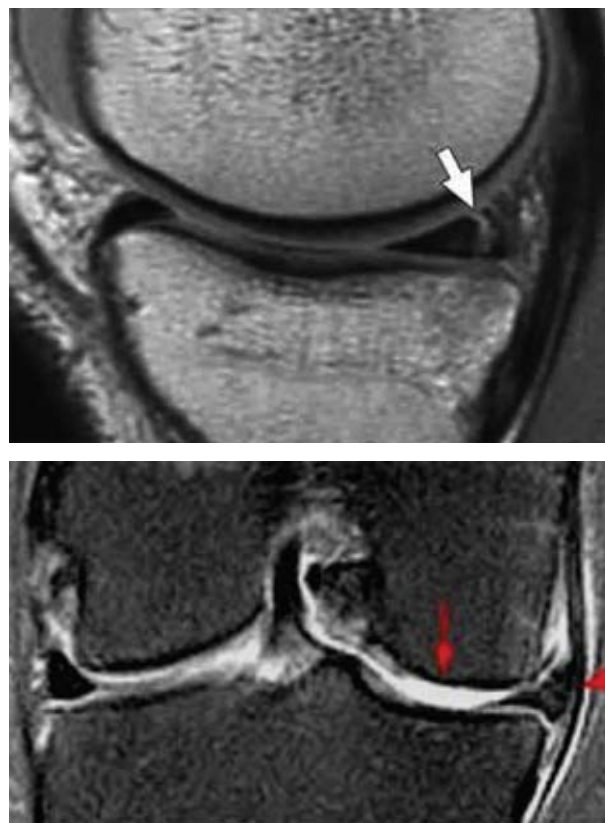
Magnetic resonance image: medial meniscal ruptures<sup>11</sup>.
